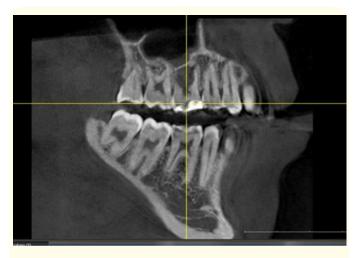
CBCT section of tooth 1.6 in the previous image.
